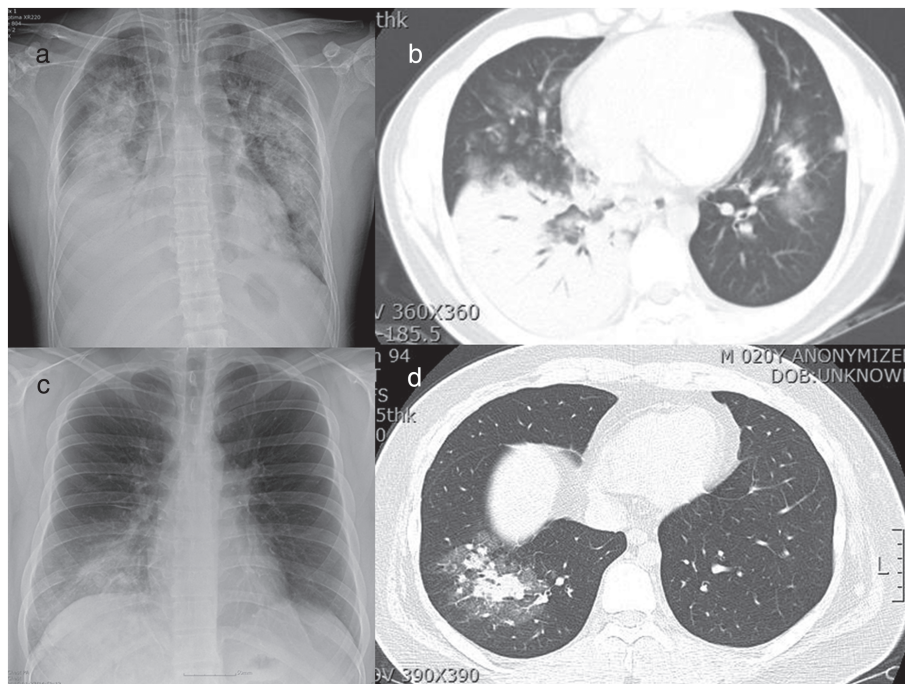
Chest radiography and computed tomography findings in adenovirus pneumonia patients. Initial chest radiography (a) in a patient who had respiratory failure initially showed prominent consolidation in the right lower lobe and diffuse infiltrates in both upper and lower lobes. The patient was intubated and received mechanical ventilation and vasopressors via a central venous catheter. Chest computed tomography (b) showed prominent consolidation in the right lower lobe with an air bronchogram and bilateral patchy ground glass opacities. Initial chest radiography (c) in a patient who had mild pneumonia without respiratory failure showed focal consolidation in the right lower lobe. Chest computed tomography (d) showed focal consolidation surrounded by ground glass opacities.
